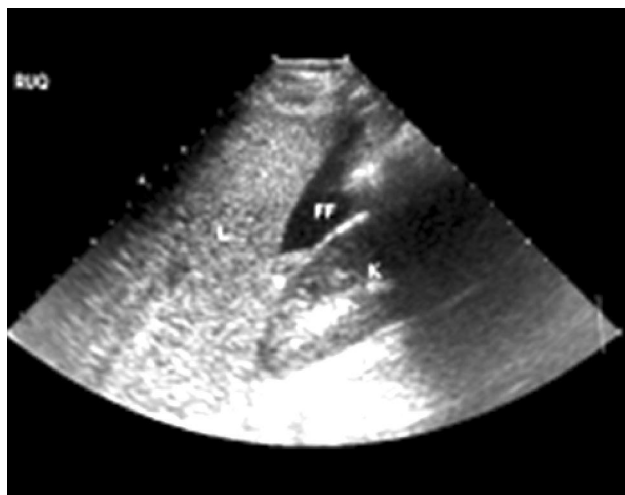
Ultrasound showing free fluid in Morrison's Pouch.
